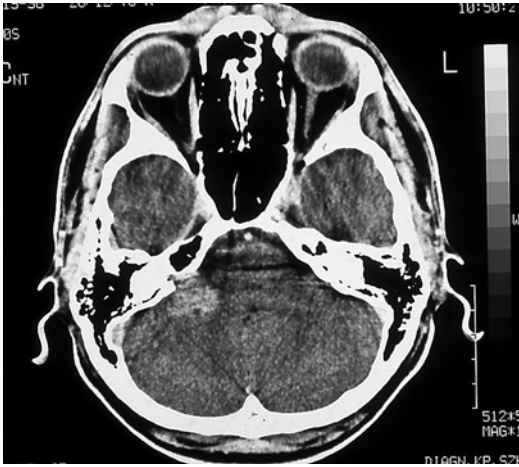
CT image of an acoustic neuroma on the right side leading to facial nerve paresis
